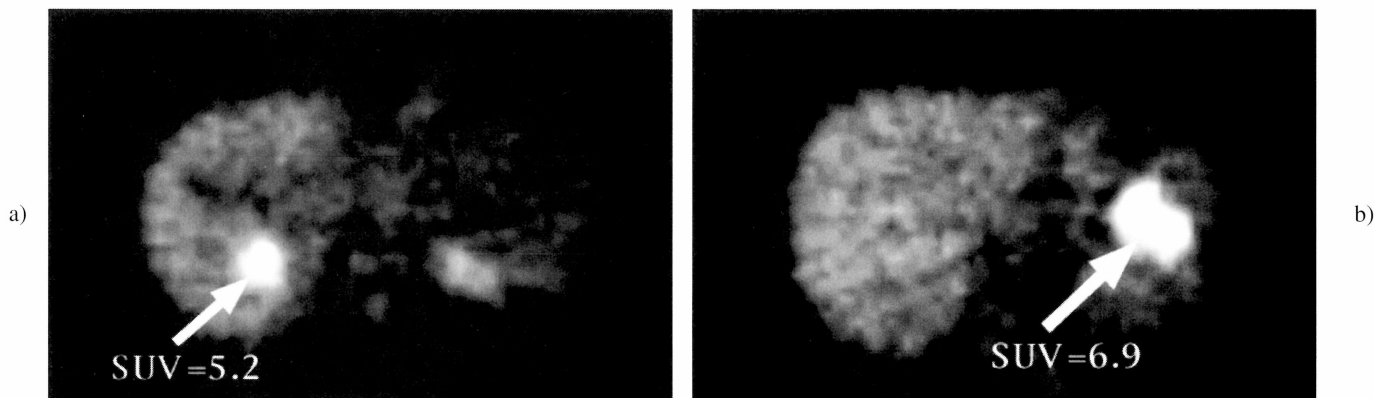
(a, b) — FDG-PET finding. FDG-uptake in the liver (SUV=5.2) (Figure 3a) and spleen (SUV=6.9) (Figure 3b) is observed.
